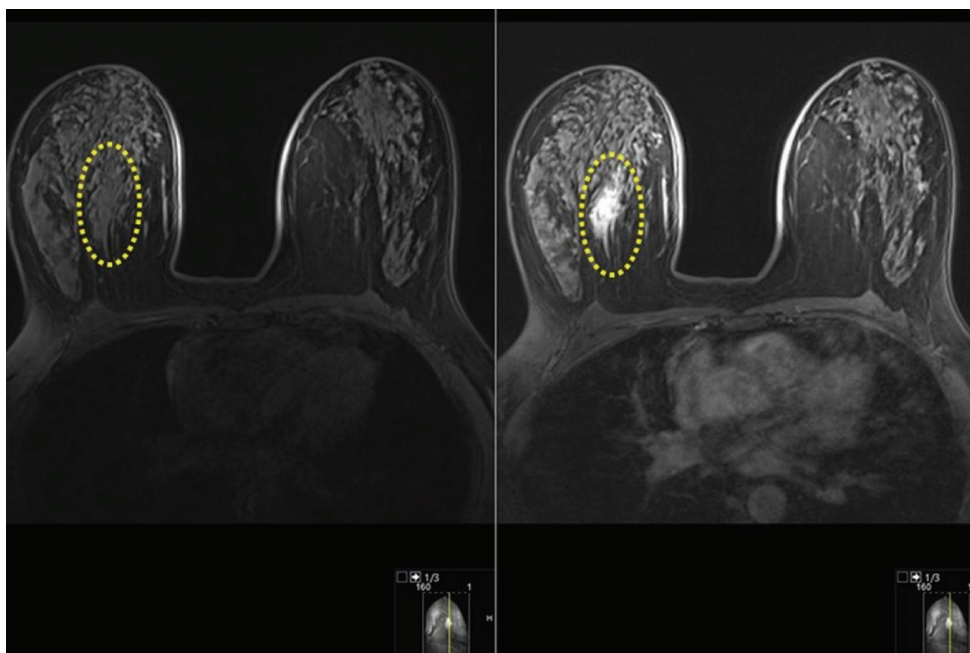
On pre-contrast T1W MRI, there was a 4 cm hypointense asymmetric lesion with irregular borders in the upper inner quadrant of the right breast. On postcontrast T1W image non-mass enhancement was seen which became more evident at a subsequent follow-up three months later
